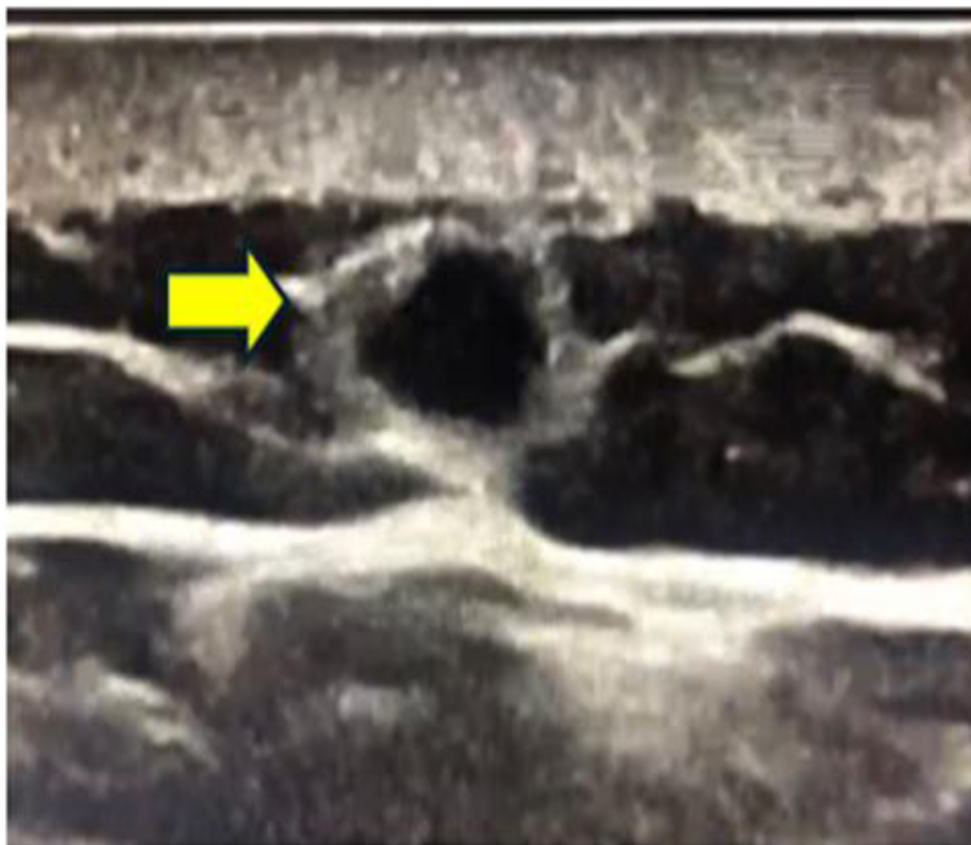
Shows a transverse ultrasound image of the deltoid muscle, demonstrating a well-defined oval hypoechoic nodular lesion, consistent with a traumatic neuroma (yellow arrow).
